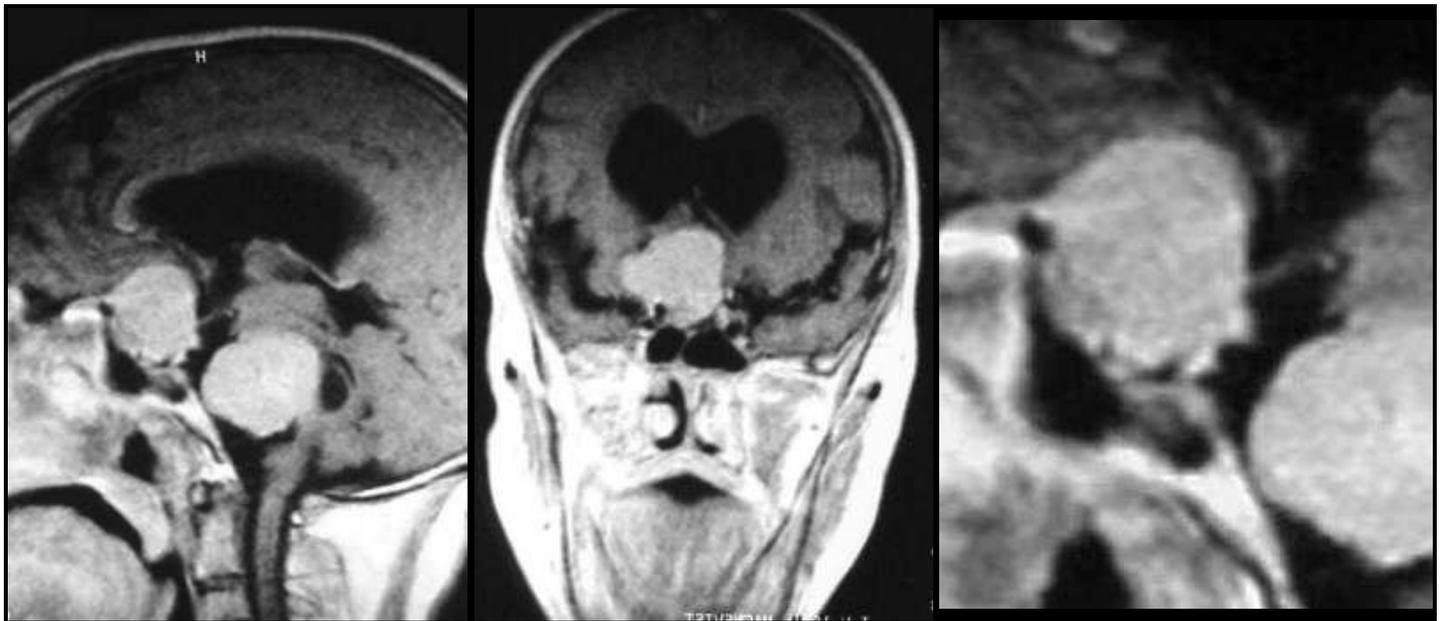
Two syncytial meningiomas. Postcontrast MRI T1 images. The two lesions showed dense and uniform contrast enhancement. Notice the meningeal tail extending from the subfrontal mass (A,C). Also notice the arachnoid cyst. Hydrocephalic changes are also seen.
